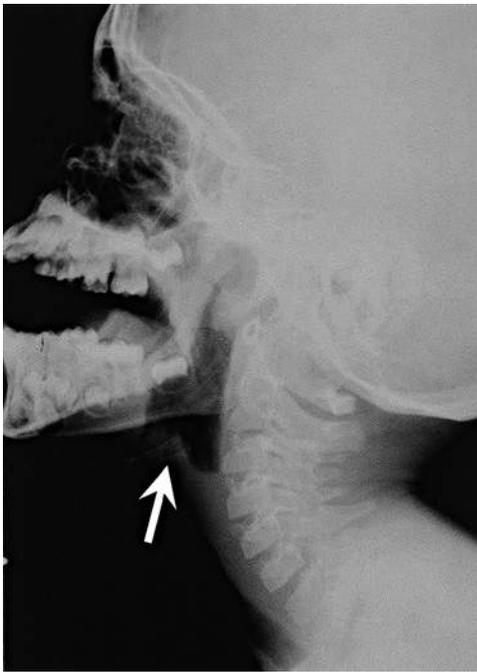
Lateral radiograph of the neck of a patient with epiglottitis. The thumb sign is prominent (arrow).
